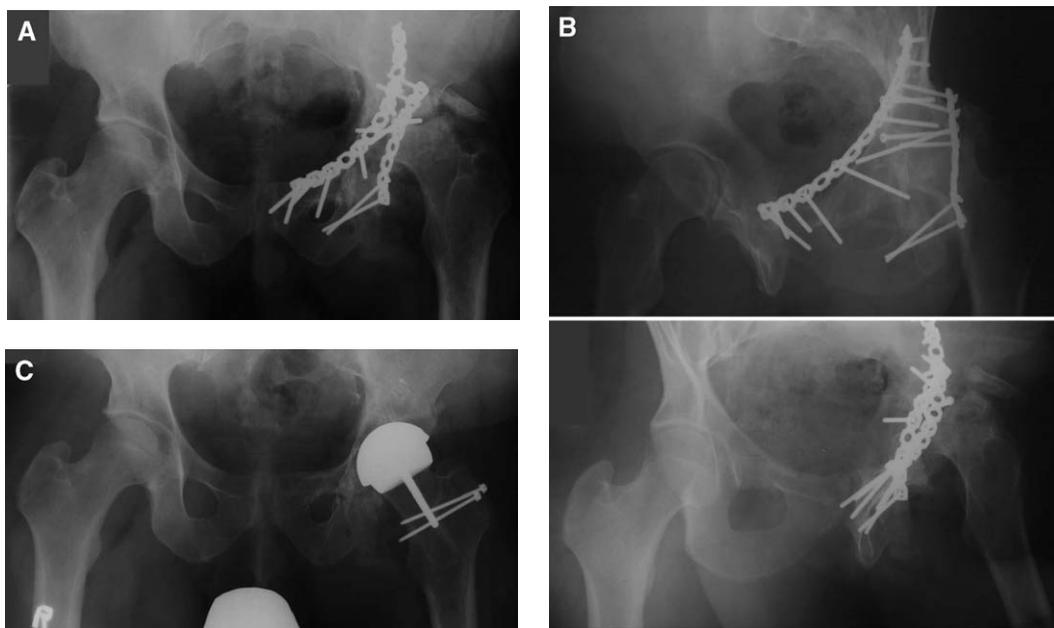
(A) Anteroposterior radiograph demonstrating the femoral head deformity and leg-length discrepancy. (B) The Judet 45° obliques demonstrate that the roof of the acetabulum is deficient but the anterior and posterior columns are relatively intact. (C) Anteroposterior radiograph post hybrid resurfacing arthroplasty.
